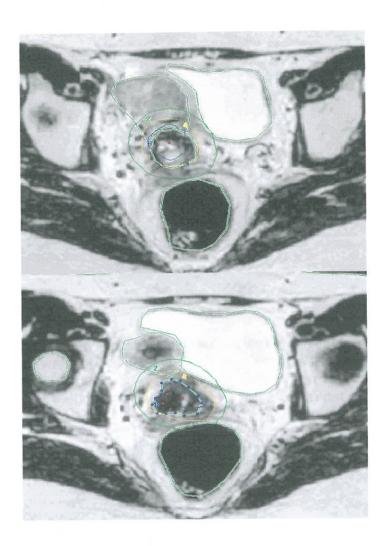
MRI-based conformal HDR BT plan. T2 weighted axial MR image with the applicator device in treatment position and the prescribed fraction isodose curves for 2, 4 and 8 Gy. The delineations of the CTV (blue dots) and the OARs; the rectum and the bladder on the sectional images are imported directly into the treatment planning system, and the dose-volume association is evaluated.
